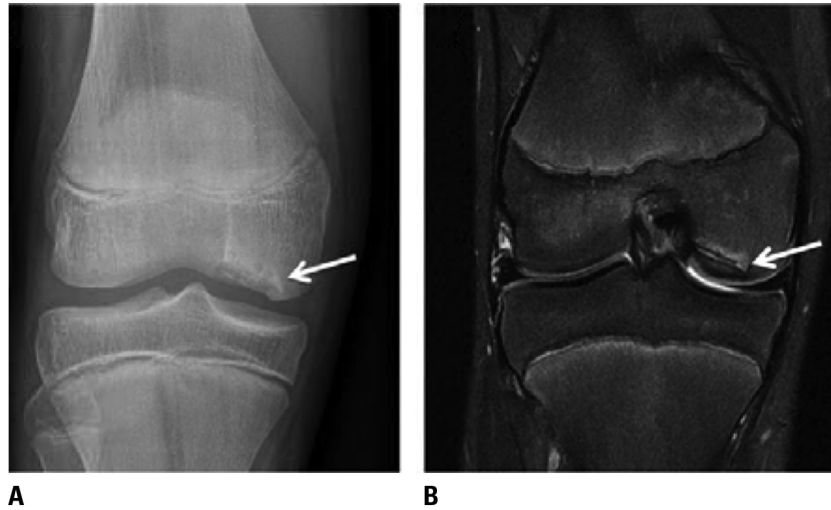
Knee osteochondral lesion. (A) Radiograph of knee depicting an abnormal lucency in the lateral aspect of the medial femoral condyle. (B) Coronal T2-weighted fat-saturated MRI of the same knee showing unstable osteochondritis dissecans (OCD) lesion with surrounding bone marrow edema.
